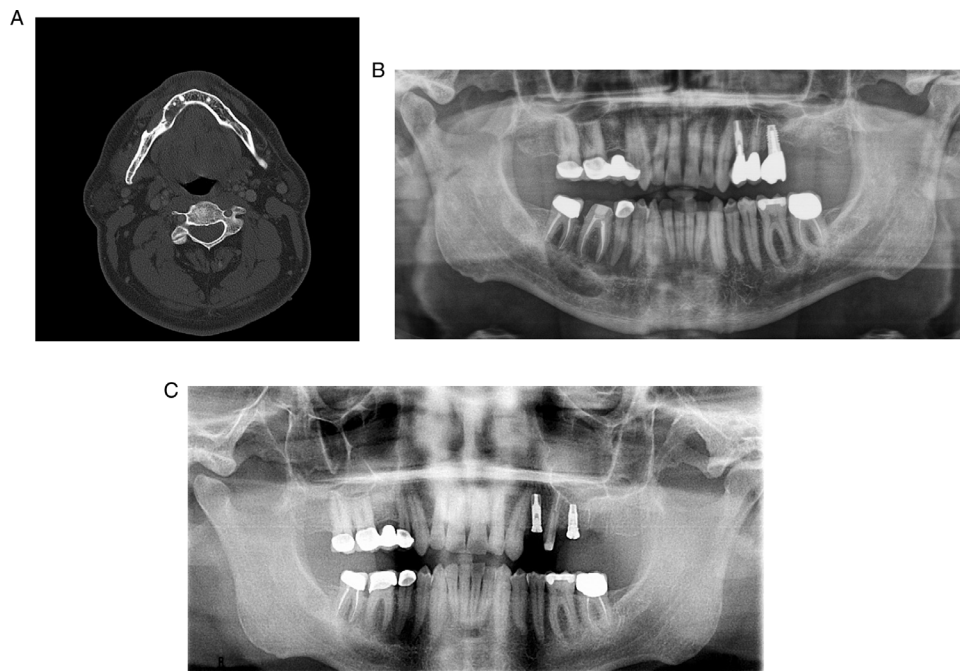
(A) Computed tomography showing an expansile lytic lesion of the right mandibular body with buccal and lingual cortical destruction. (B) Panoramic radiograph at the consultation visit showing a radiolucency involving the roots of teeth 27 to 31. (C) A panoramic radiograph taken 12 years previously showing a radiolucency centered around the roots of tooth 30.
